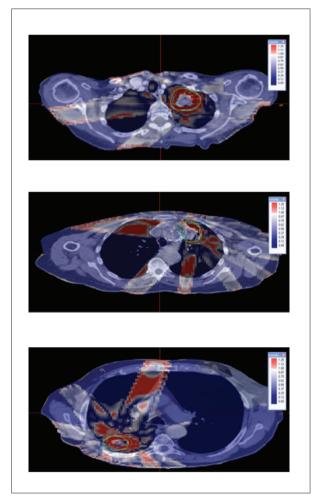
Images generated from the co-registration of the gamma function image with the corresponding CT slice.
